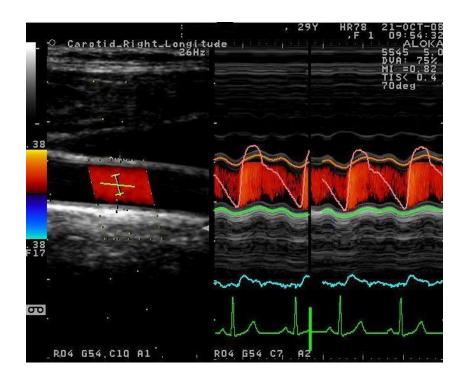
Simultaneous recordings of velocity and diameter-derived pressure used to derive wave intensity signals. The vertical cursor on the longitudinal image shows the m-mode recording position (displayed on the right). Echo-tracking software follows diameter changes of the near and far carotid adventitia (orange and green lines). From this a diameter waveform is constructed (shown in pink) which can be calibrated with brachial systolic and diastolic blood pressure. The flow velocity waveform derived from Doppler information is shown in blue.
